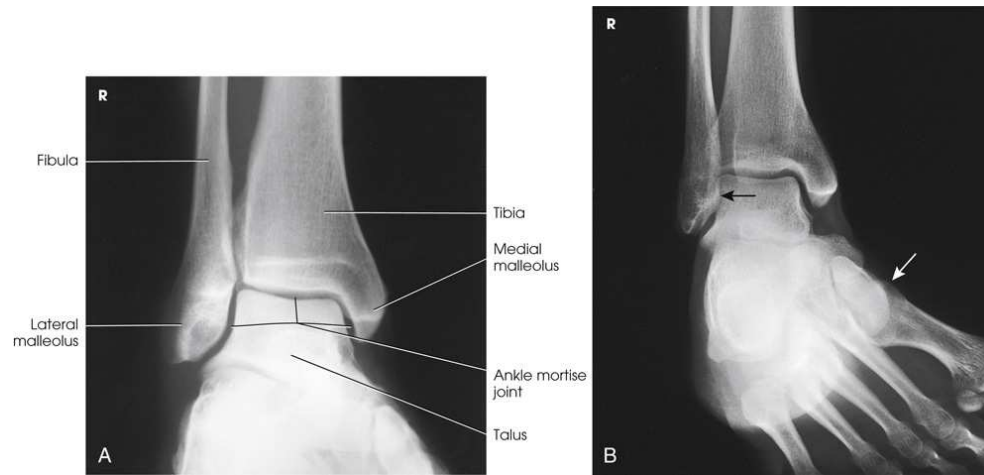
AP oblique ankle, 15- to 20-degree medial rotation to show ankle mortise joint. (A) Properly positioned leg to show mortise joint. (B) Poorly positioned leg; radiograph had to be repeated. The foot was turned medially (*white arrow*), but the leg was not. Lateral mortise is closed (*black arrow*) because the “leg” was not medially rotated.
